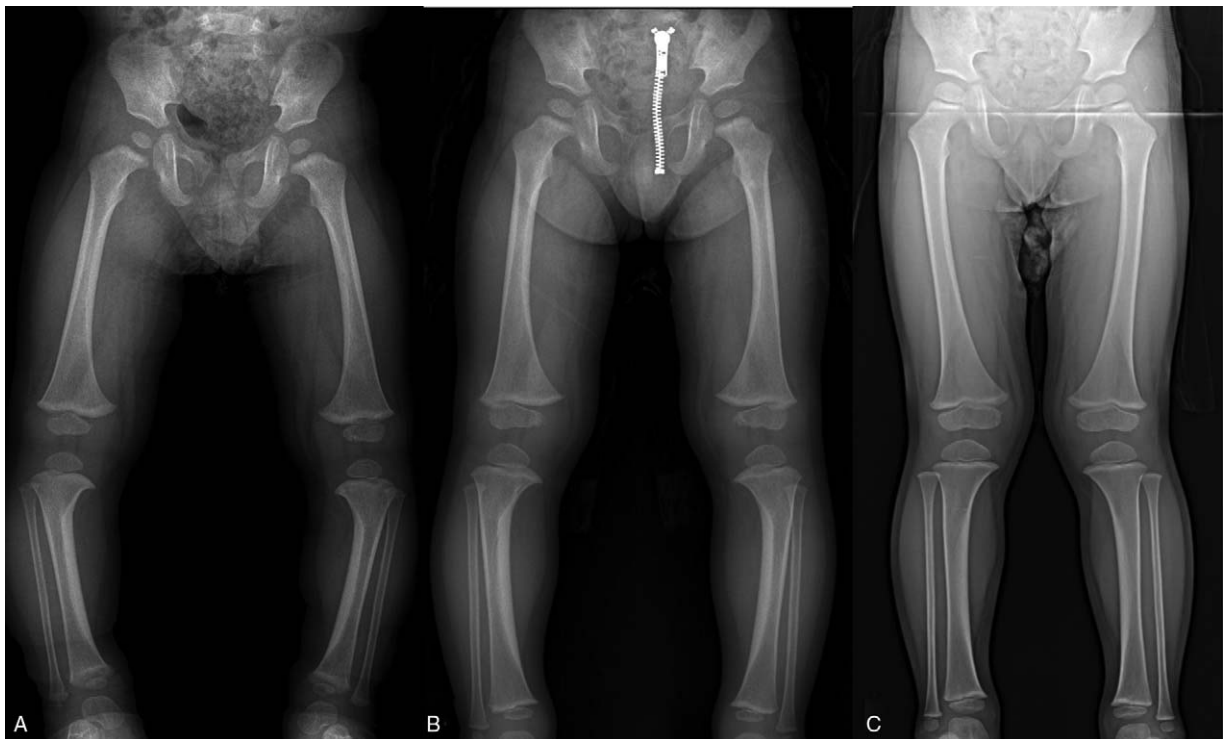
A 15-month-old boy presented with bilateral bow-leg deformities. (A) At the initial visit, radiographs revealed tibial metaphyseal-diaphyseal angles (TMDAs) of 13° on the right and 12° on the left. (B) There was slight improvement after 4 months, with TMDAs of 9° on the right and 10° on the left. (C) Radiograph showing definite improvement at the age of 31 months. The TMDA measured 0.5° on the right and 0.5° on the left.
